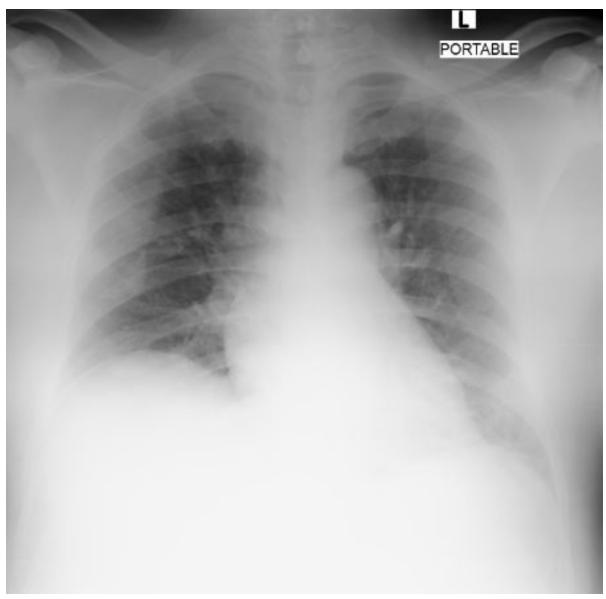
Chest X-Rays Report (26 June 2020): Perihilar bronchial cuffing and tram tracking is suggestive of bronchitis. No discrete consolidation or groundglass opacity to suggest a fulminant Lower respiratory tract infection or COVID-19.
